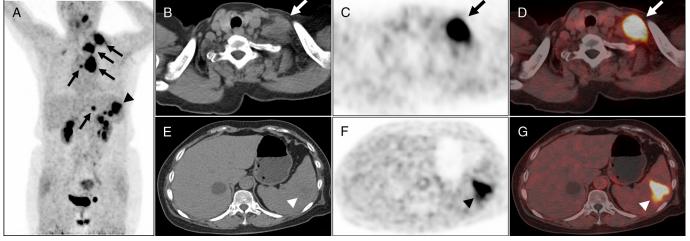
⁶⁸Ga-FAPI PET/CT was performed to further differentiate benign and malignant diseases. The patient was enrolled in the prospective study evaluating the role of ⁶⁸Ga-FAPI PET/CT in the management of malignant tumors, which was approved by Shanghai Cancer Center Institutional Review Board (ID 2004216-25), and written informed consent was obtained from the patient. The MIP, axial CT, PET, and fusion PET/CT images of ⁶⁸Ga-FAPI PET/CT showed intense ⁶⁸Ga-FAPI uptake in the aforementioned FDG-avid lymph nodes (A–D; arrows, SUV_{max}, 20.1) and spleen lesions (A, E–G, arrowhead; SUV_{max}, 11.7). According to the results of ¹⁸F-FDG and ⁶⁸Ga-FAPI PET/CT, the most likely diagnosis was malignant tumor.
